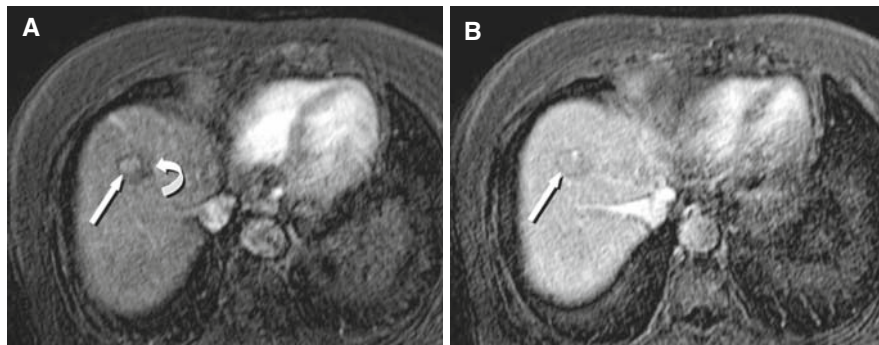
“Nodule-in-nodule appearance” of HCC. (A) Arterial phase MRI shows faint enhancement (*arrow*) of the HCC within the larger hypointense dysplastic nodule (*curved arrow*). (B) Portal venous phase MRI shows the internal HCC nodule as iso- to hypointense to liver (*arrow*).
